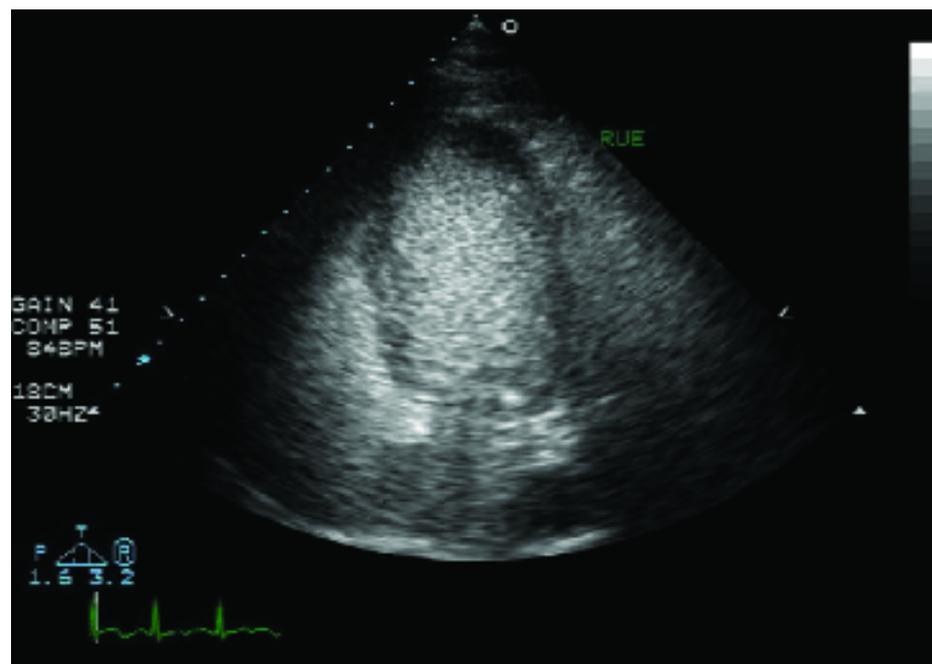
Apical four-chamber echocardiographic view demonstrating agitated saline bubble study where all four chambers are opacified, suggesting a right-to-left intracardiac shunt.
